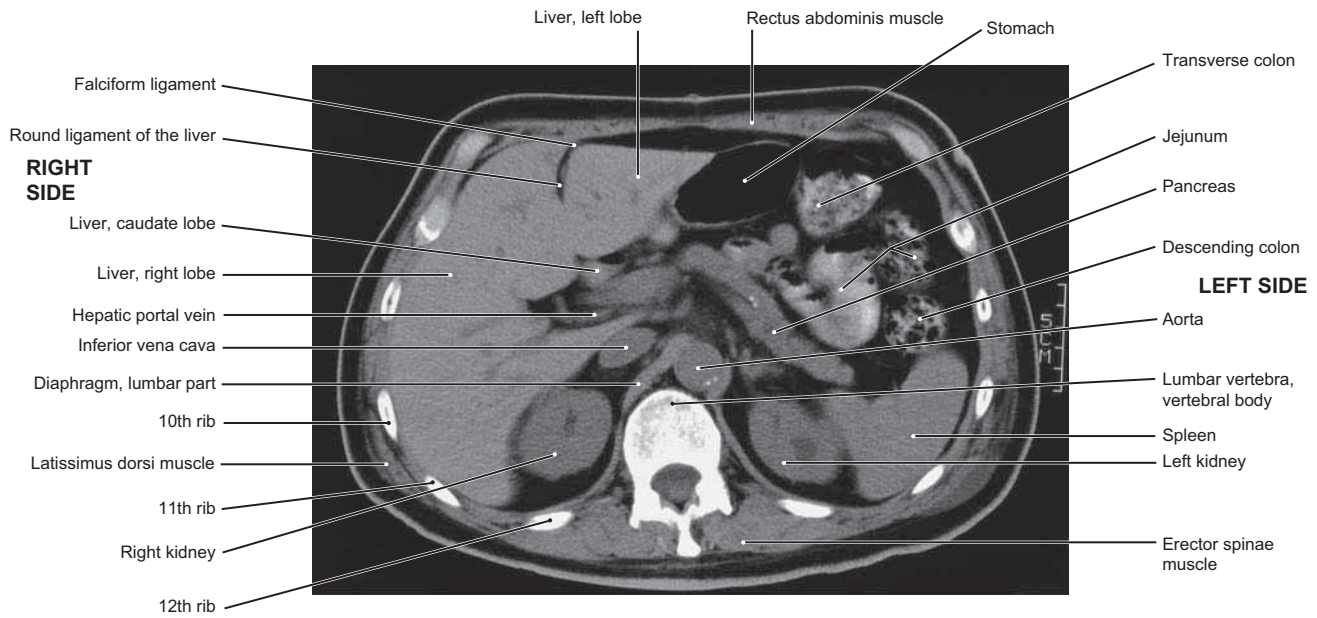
CT of Transverse Section of the Abdomen at L1 (Caudal Aspect)
